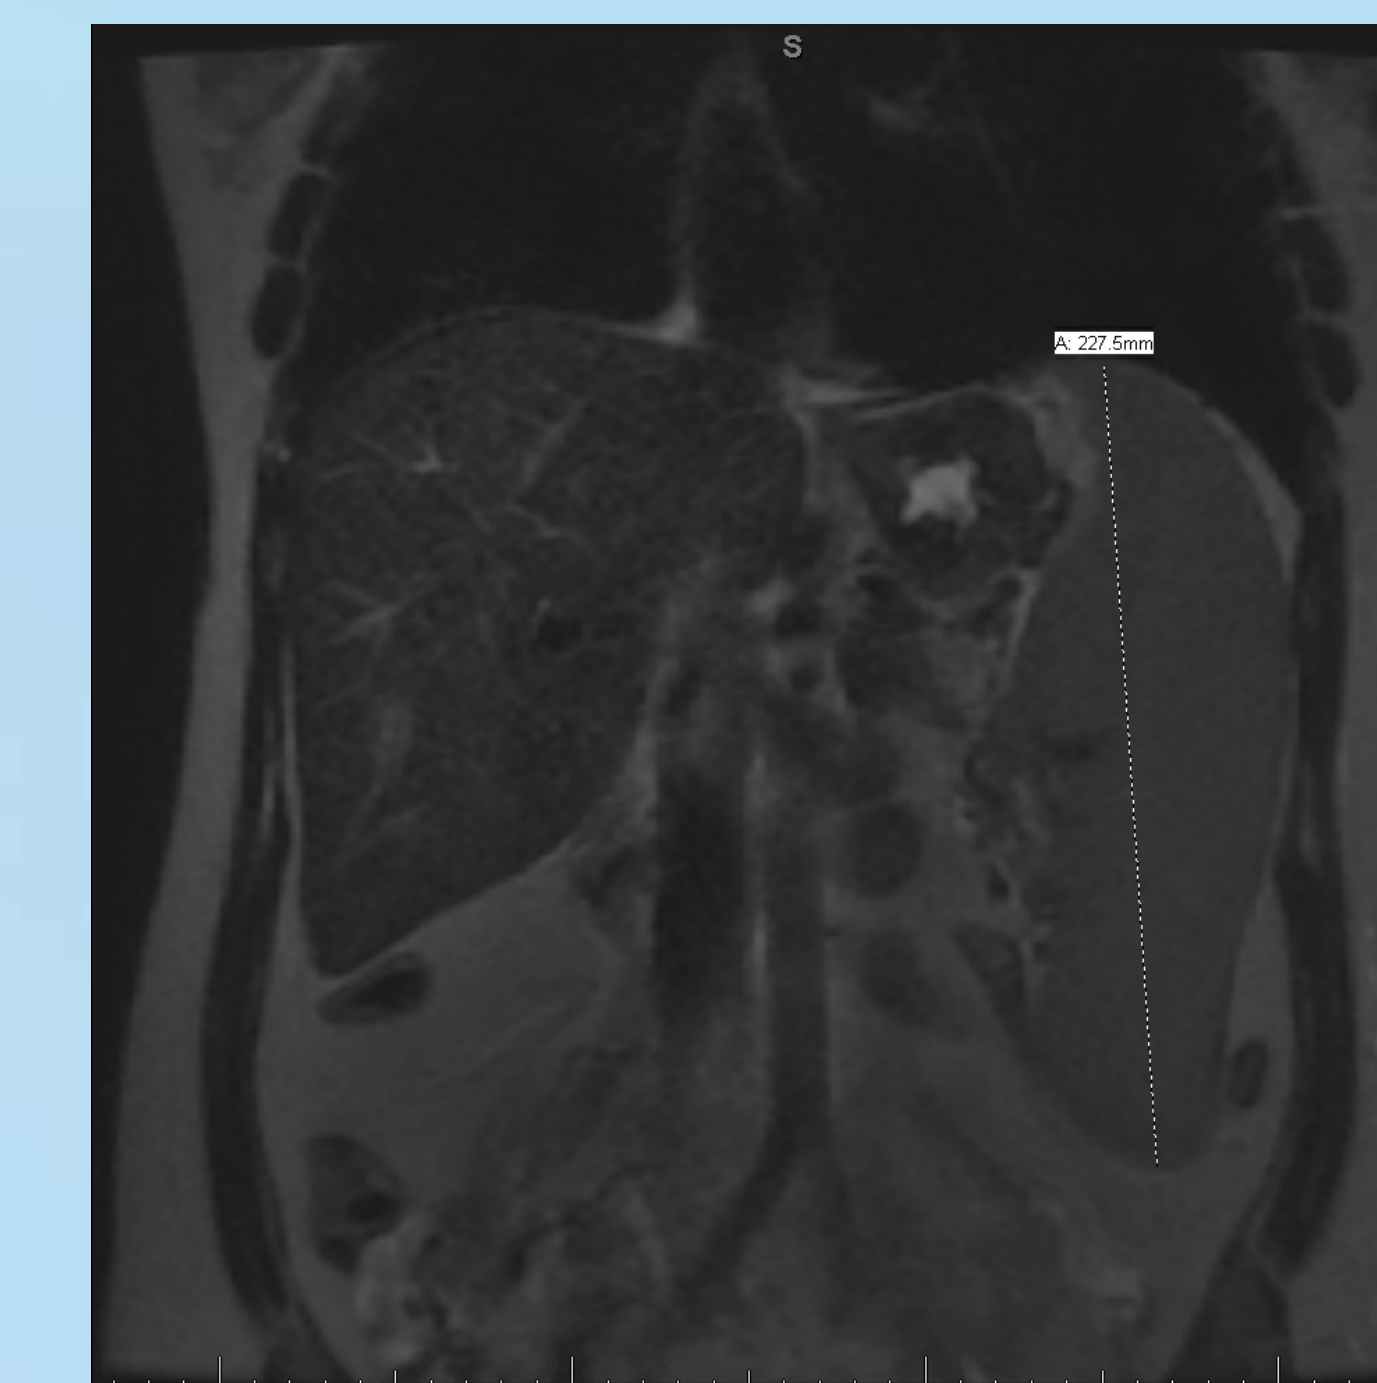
MRI of abdomen and pelvis in coronal view noting massive splenomegaly measuring 22.75cm crainocaudad.
